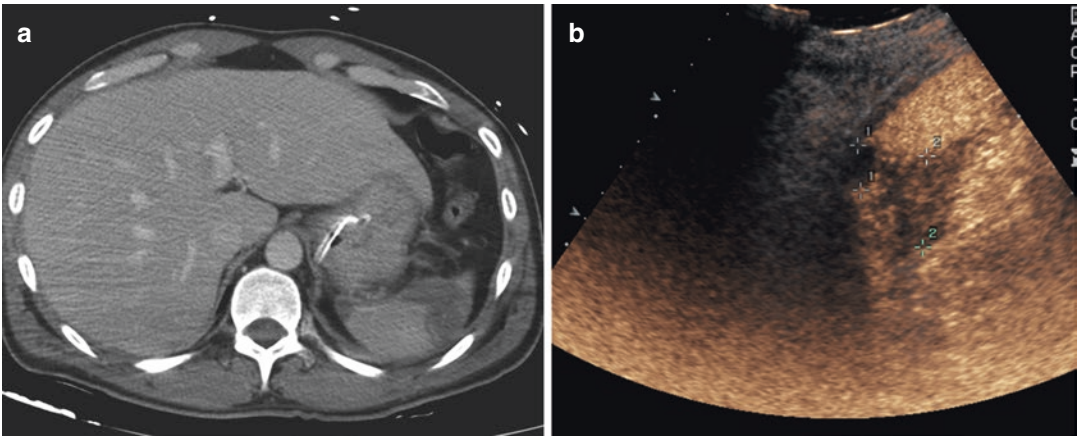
Follow-up 3 days later. Contrast-enhanced CT (a) and CEUS (b) depict well a laceration area of the lower spleen pole, contacting the splenic capsule
